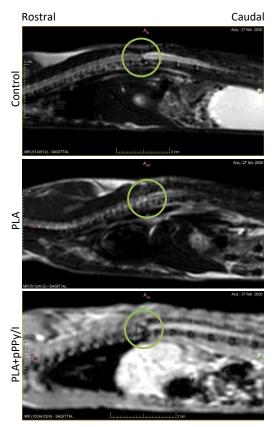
MRI analysis on the 2^{nd} week. T2W (control and PLA) and T1W (PLA+pPPy/I) sagittal view images showing the injury site.
